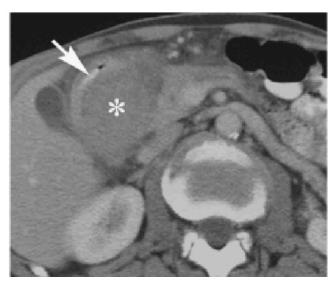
Repeat CT scan of the patient with worsening exam findings show duodenal contusion with adjacent hematoma (*). No free air is seen. From Figure 37.4 of Levy AD, Mortele K, Yeh BM, eds. *Gastrointestinal Imaging Cases*. Oxford, UK: Oxford University Press; 2013.
